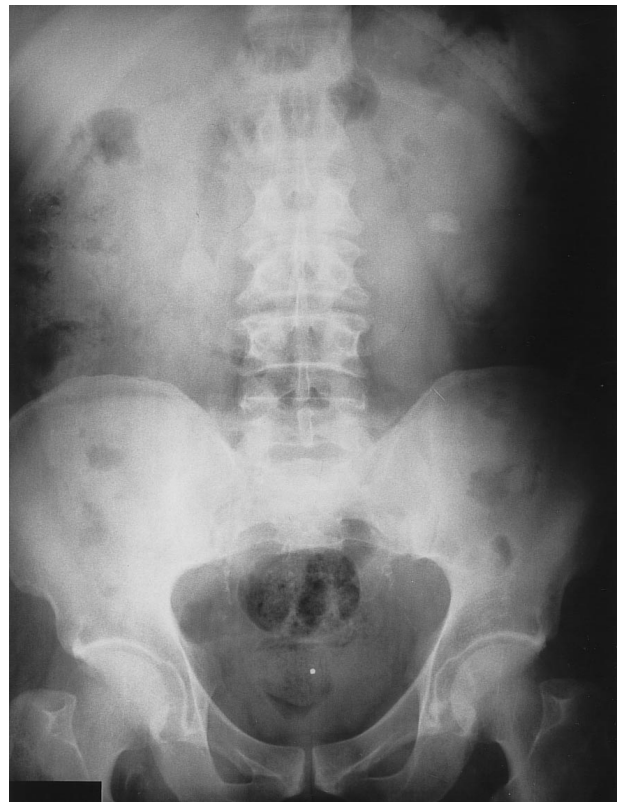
Abdominal plain radiograph before ESWL, showing the calcium-containing stone in the left kidney. Bilateral vascular calcifications are also detectable.
